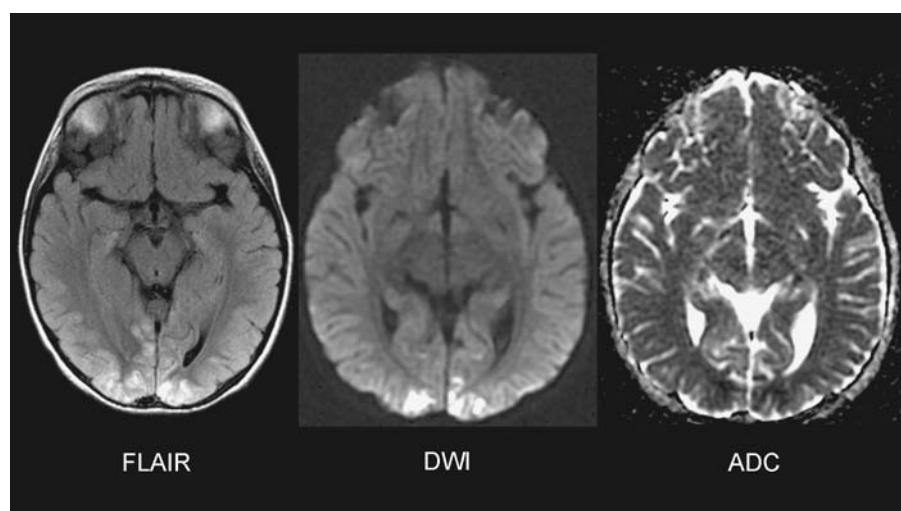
Thirty-five-year-old male with diabetes and hypoglycemia. There are bilateral occipital lobe lesions that are FLAIR and DWI hyperintense. The lesions are ADC hypointense, consistent with decreased diffusion due to low glucose. The MRA (not shown) showed a normal posterior circulation. Abbreviations: FLAIR; fluid-attenuated inversion recovery, DWI, diffusion-weighted images; ADC, apparent diffusion coefficient; MRA, magnetic resonance angiography.
